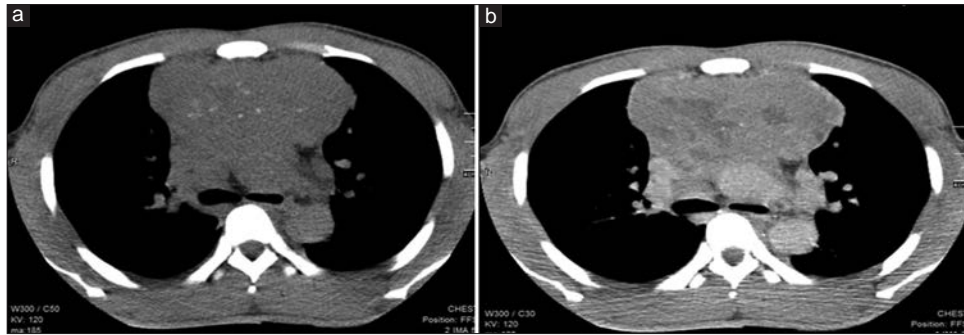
(a) Axial noncontrast computed tomography image at the level of the hilum showing lobulated isodense mass in the anterior mediastinum. Stippled hyperdense lesions of calcific density are also noted within the mass. The main bronchi are compressed (original image) (b) Contrast-enhanced computed tomography image at the level of the hilum as in Figure 4a showing heterogeneous enhancement following intravenous contrast administration (original image)
